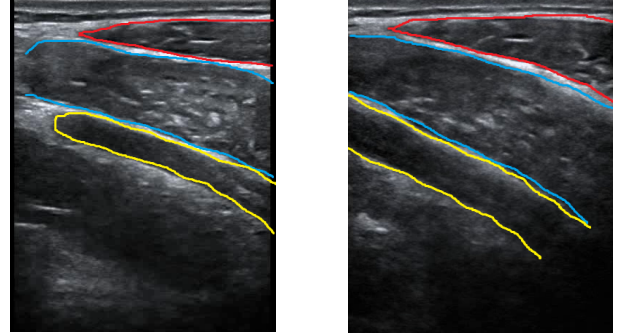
Annotated ultrasound image, with the obliquus internus (in blue) and transversus abdominis (in yellow) muscles
